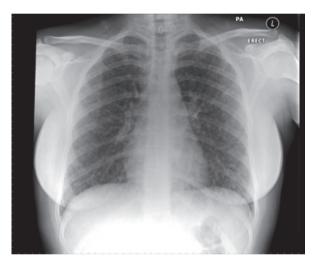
Chest X-ray showing miliary shadowing throughout both lung fields.
